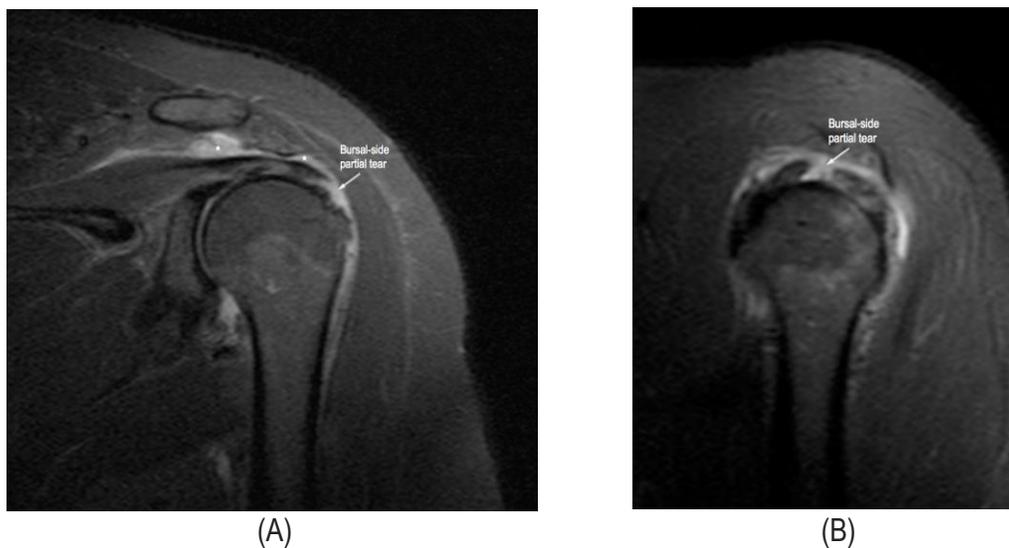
Coronal (a) and sagittal (b) MRI showing a severe sub-acromial bursitis (asterisk), a tendinopathy with bursal-side partial thickness tear of the supraspinatus tendon (arrow), and a modest amount of fluid in the gleno-humeral joint.
